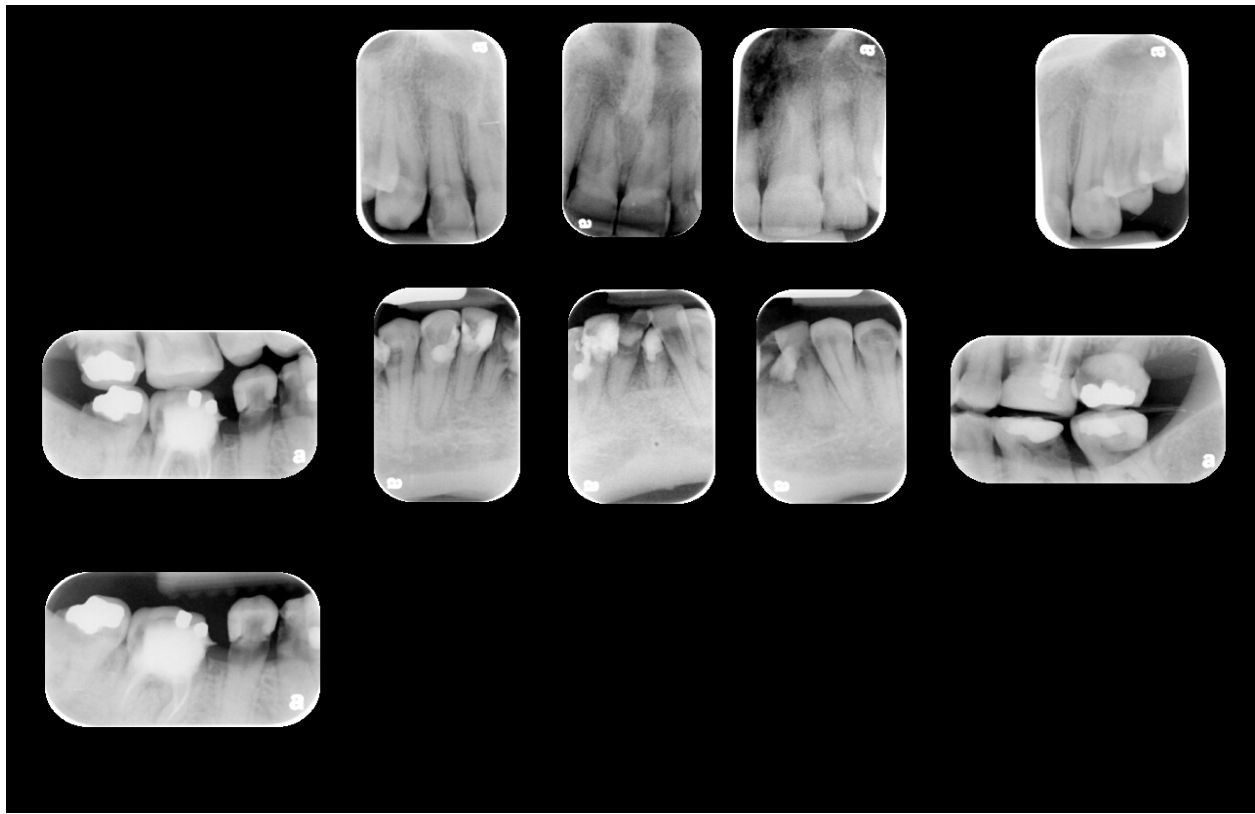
Radiographic findings of radiation related caries
